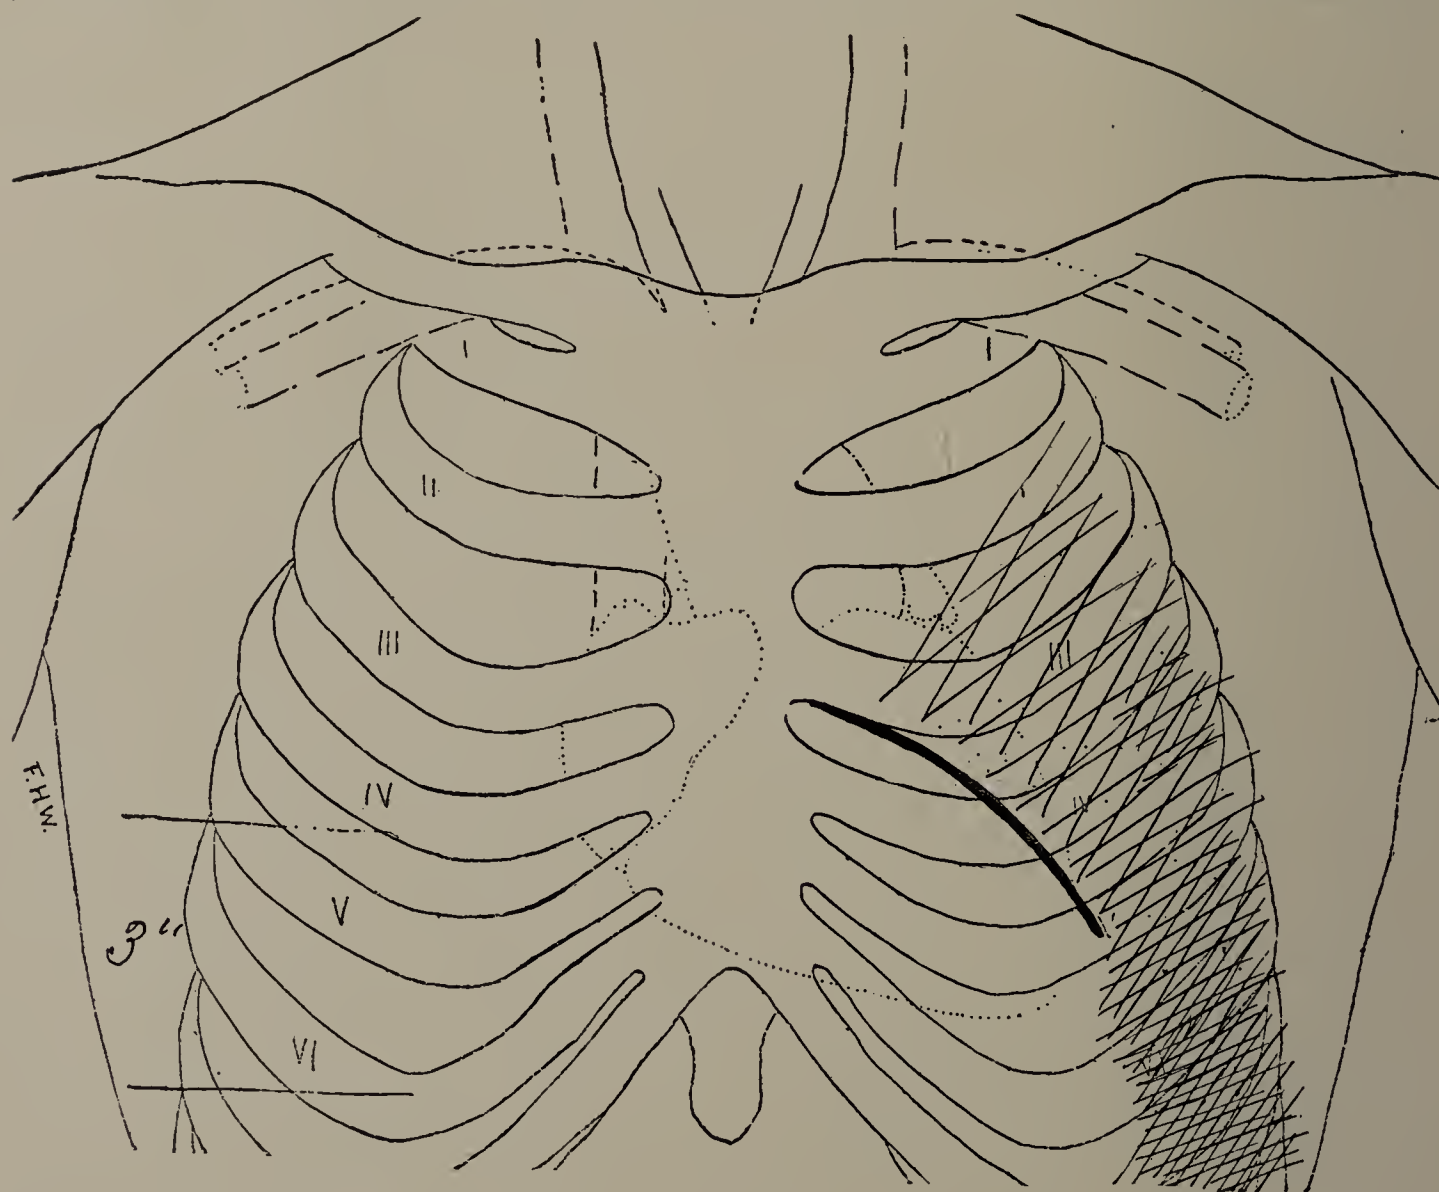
Thomas R. June 5. Fifth X-ray examination with screen. Left side, ribs seen from first to fourth rib, though less clearly than on right side. Portion of left border of heart visible; no diaphragm lines seen on left side, even in full inspiration. Excursion of diaphragm on right side. 7.5 centimetres (3 inches). (Cut one-third life size.)
